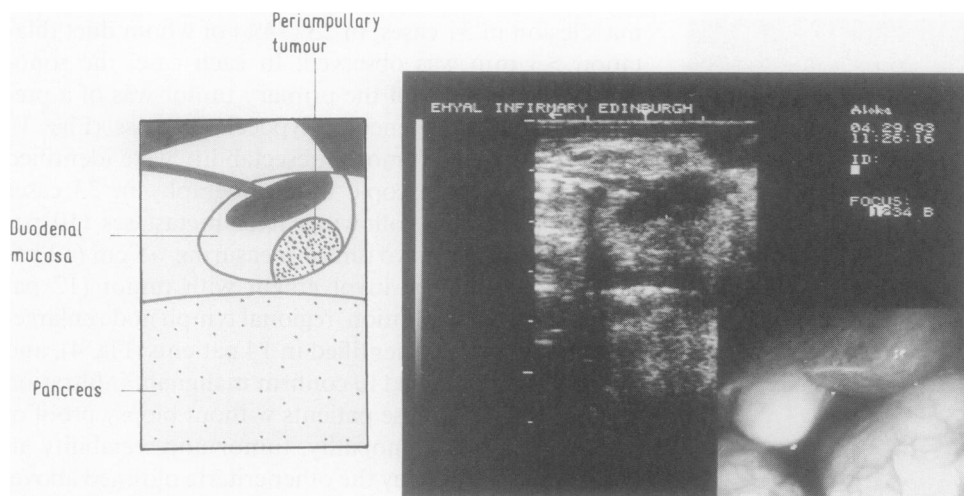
Laparoscopic ultrasonography was performed in a patient suspected of having a periampullary tumor, causing obstructive jaundice, although no mass lesion was identified by other investigations. The linear-array probe has been placed on the duodenum (insert), and the rectilinear sonogram obtained defined a 10-mm periampullary carcinoma. This tumor was deemed to be resectable and subsequently was excised by transduodenal local resection.
